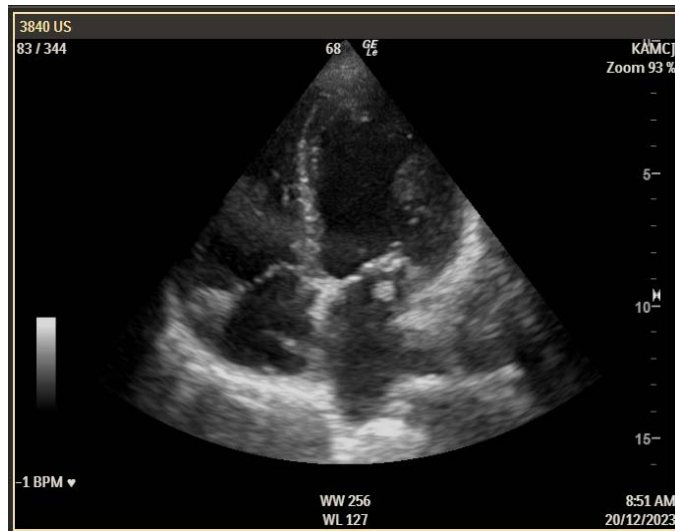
Transthoracic echo before the operation showing a mobile large vegetation on the atrial side of the mitral valve.
